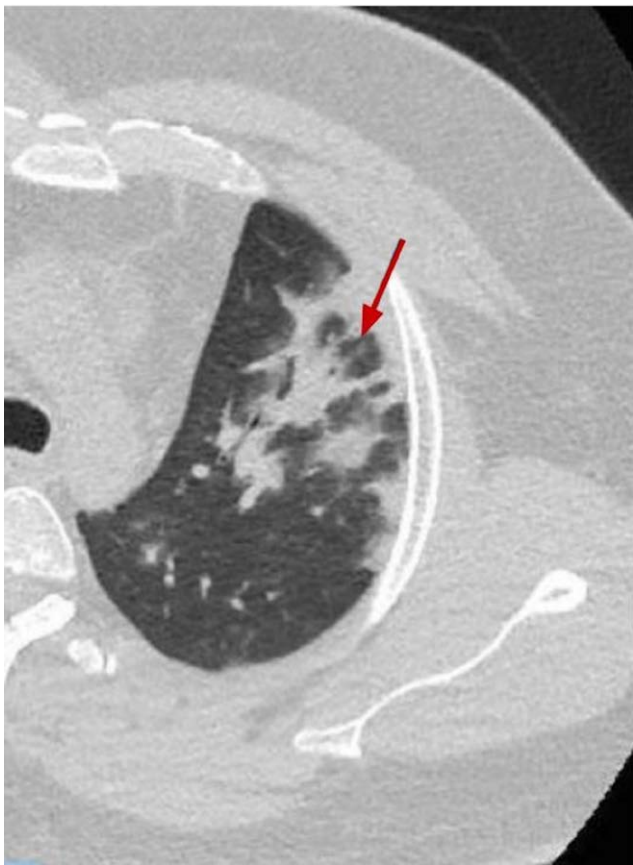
An axial CT scan with lung window settings showing consolidation in the left upper lobe, containing a focus of preserved airspace (arrow).
